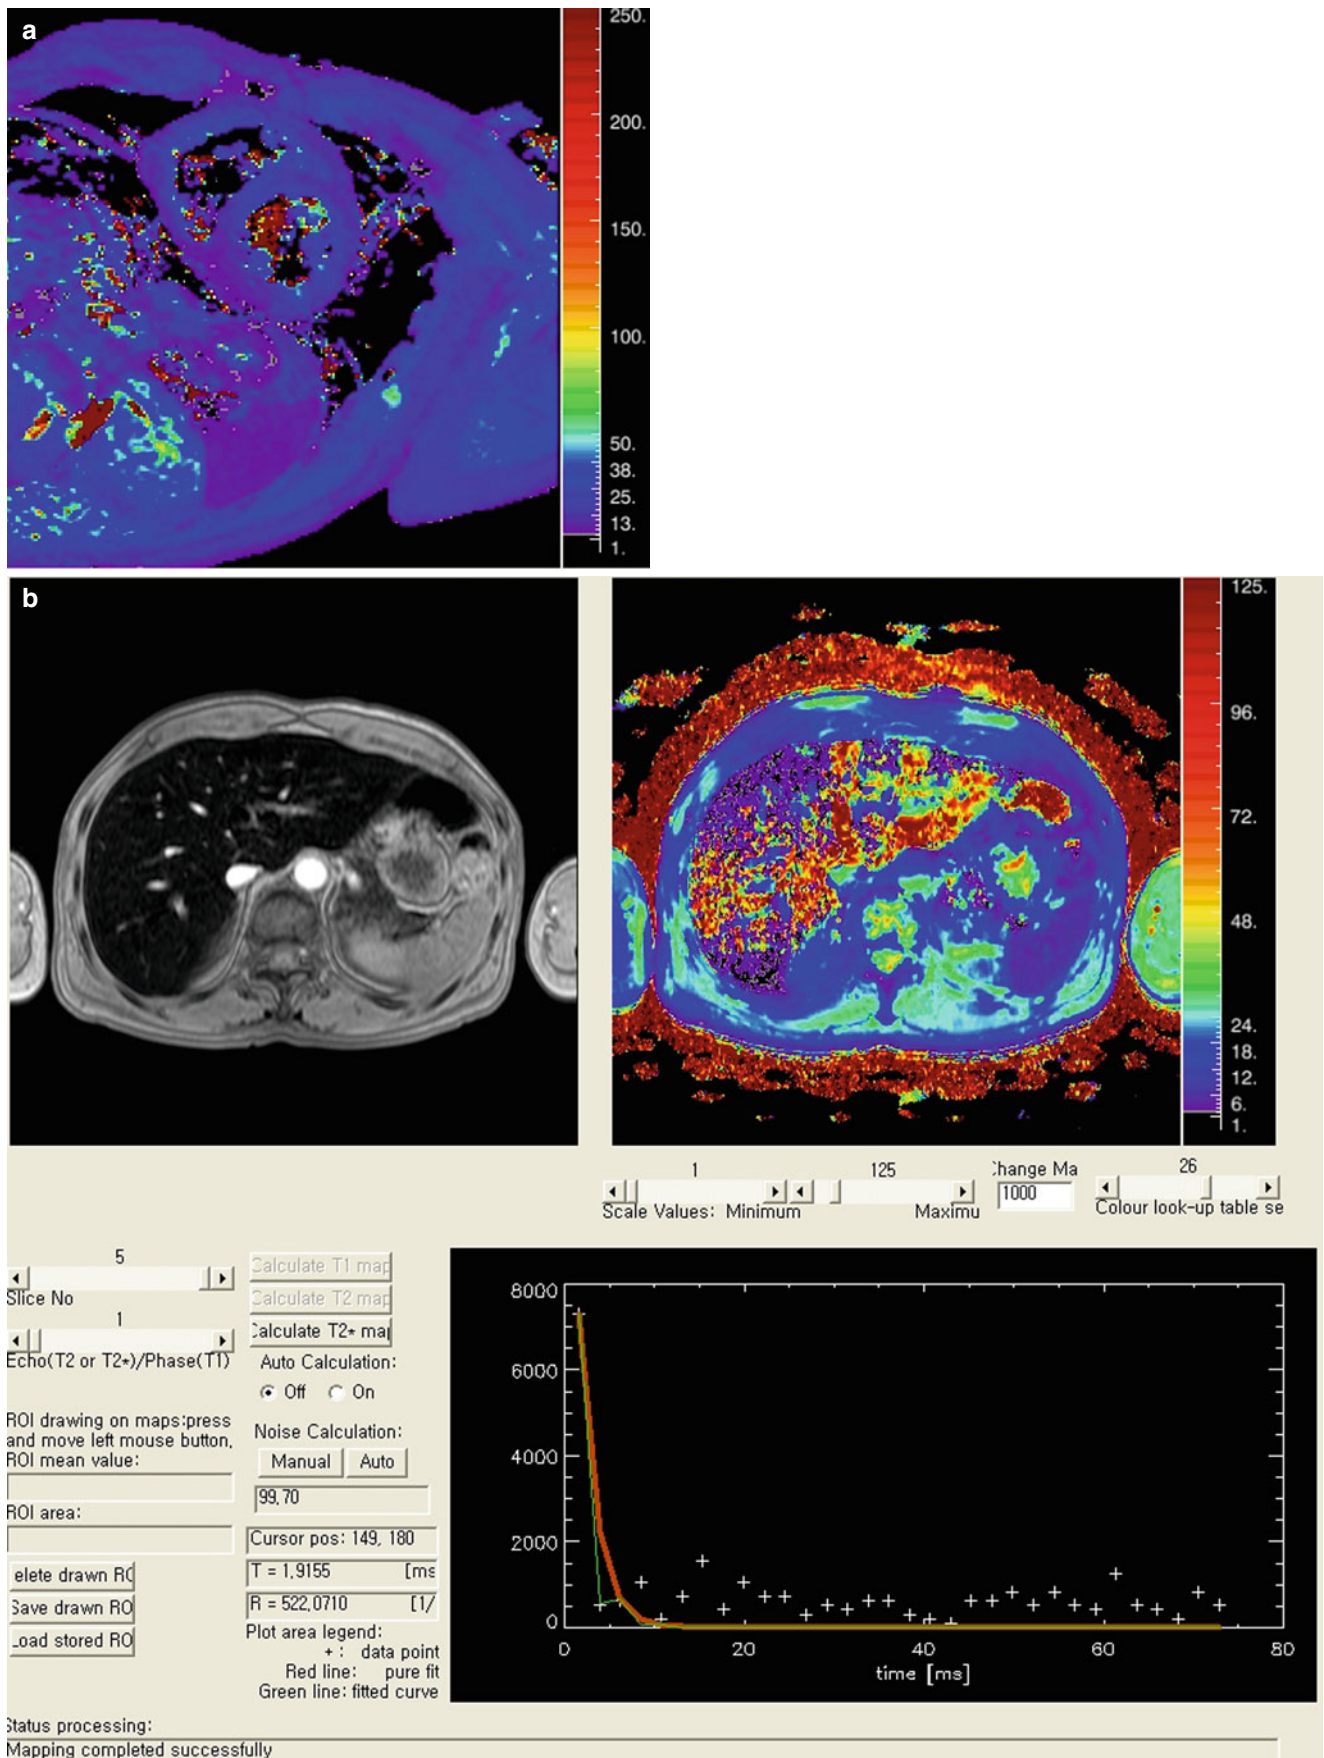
T2* mapping MRI from a patient with aplastic anemia and hemochromatosis. (a) T2* maps of the heart (b). T2* map of the liver. The T2* value of the heart is 14 ms (suggestive of myocardial iron overload) and that of the liver is 1.2–1.8 ms
